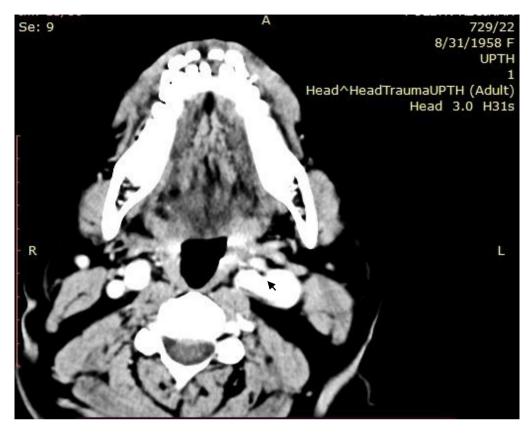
Contrast axial CT showing a Left IC-IJV AVF (indicated by the arrow)
